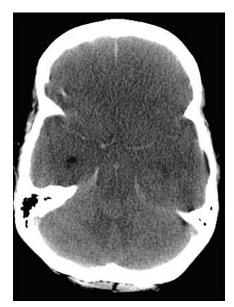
Axial noncontrast CT image at the level of midbrain shows characteristic appearance of diffuse SAH with arrow pointing to blood collection in interpeduncular cistern suggestive of ruptured basilar tip aneurysm. Please note the early developing hydrocephalus with dilated bilateral temporal horns.
